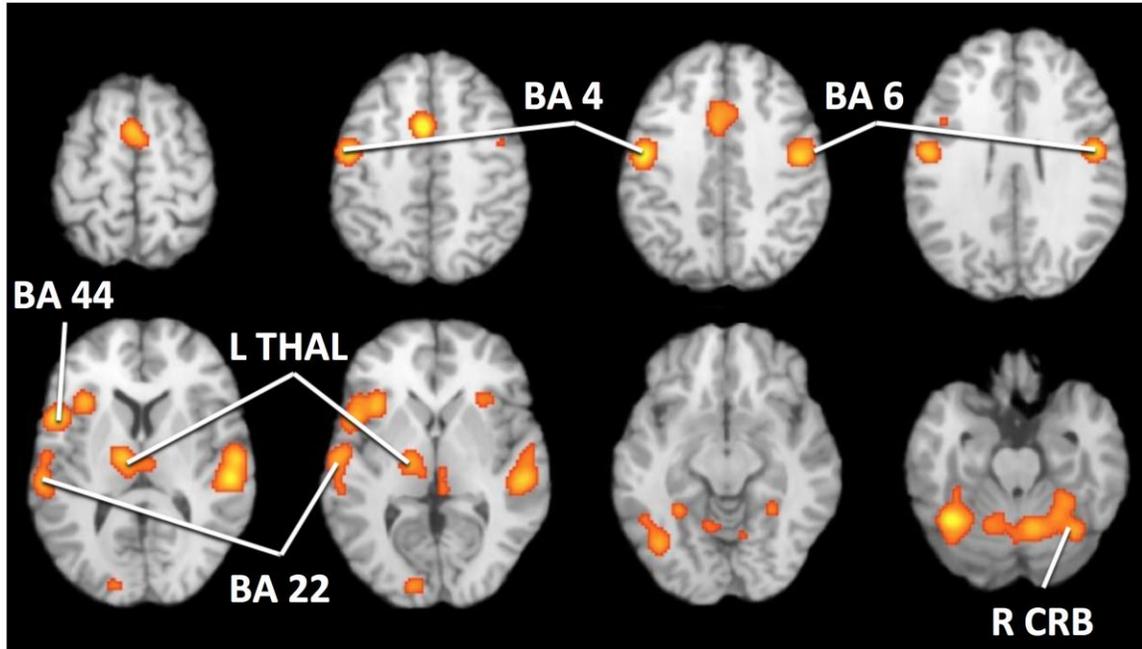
Major ALE foci clusters visualized on a standard MRI series.
